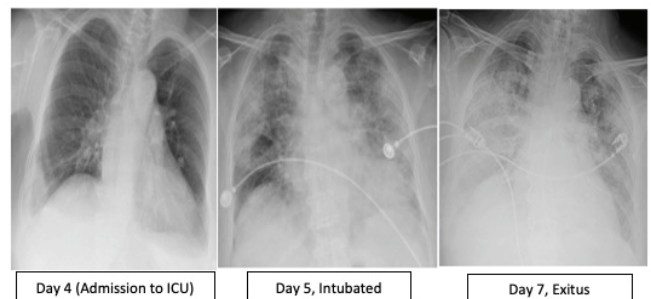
Chest X-ray images taken in the intensive care unit of the patient
